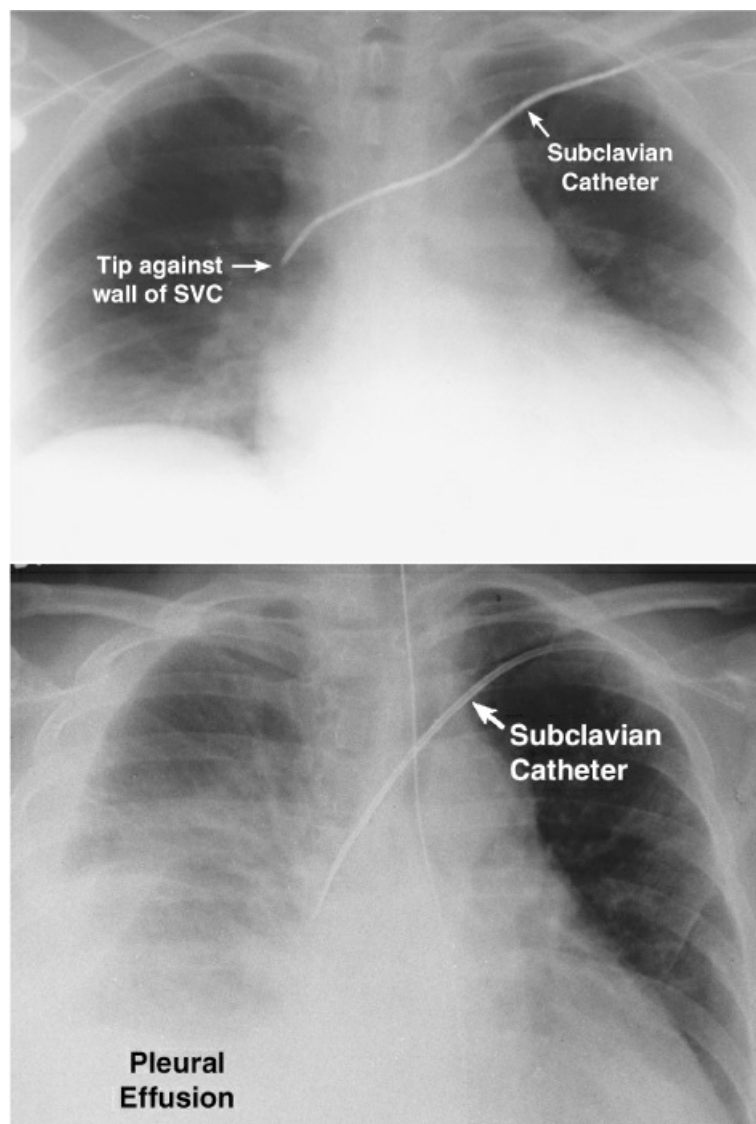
Chest x-rays showing a subclavian vein catheter that is positioned to perforate the superior vena cava (upper panel), and a similarly positioned catheter that has perforated the vena cava (lower panel). Lower chest x-ray from Reference 24.
